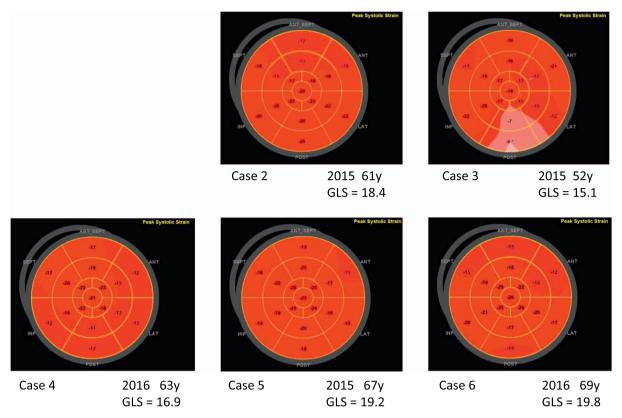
Myocardial strain analysis by speckle-tracking echocardiography. Case 2, at age 61, EF 64%, GLS 18.4%. Case 3, at age 52, EF 48%, GLS 15.1%, Note low strain in the basal to midposterior wall indicating abnormal regional myocardial contractile ability. Case 5, at age 67, EF 62%, GLS 19.2%. Detail of each case were described in Supplemental Table 2.
